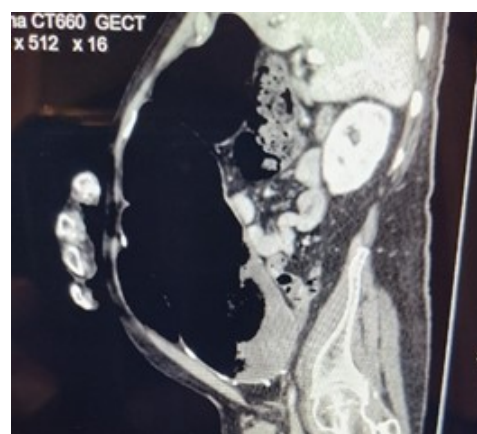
CT with contrast: showing entire colonic dilation measuring 10 cm, extending to the rectosigmoid colon and anus with no abscess or mass in sagittal view.
